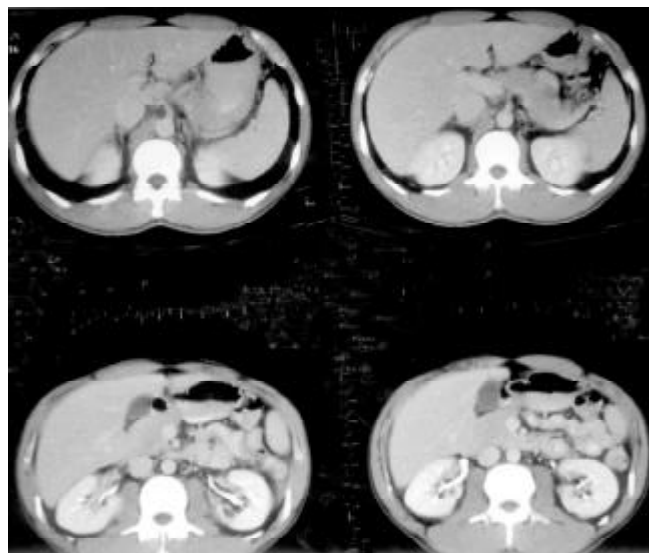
No evidence of hepatocellular tumor seen on upper abdominal CT with contrast.
